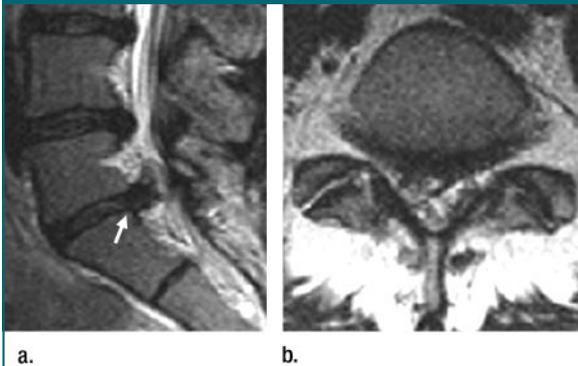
Extruded disk herniation. (a) Right parasagittal and (b) transverse T2-weighted fast SE images (4000/120) through lumbar spine and L5-S1 disk space. Extruded disk herniations are characterized by a base that is narrower than the distance of disk material extension beyond the disk space (arrow).
